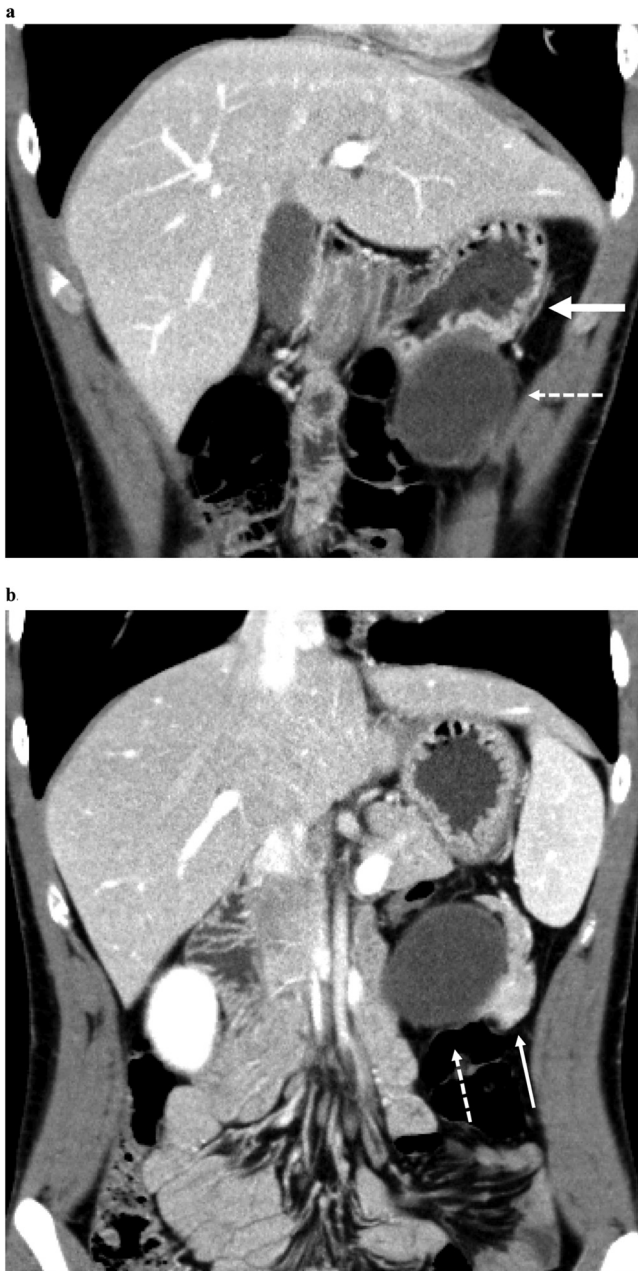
(a,b) CT shows a well-circumscribed homogenous low-density mass measuring 6.2×6.0 cm (dotted arrow) between the upper posterior wall on the gastric greater curvature (thick arrow) and the pancreatic tail (thin arrow). The mass seems to originate from the pancreatic tail. The pancreatic tail stretches to the caudal side.
